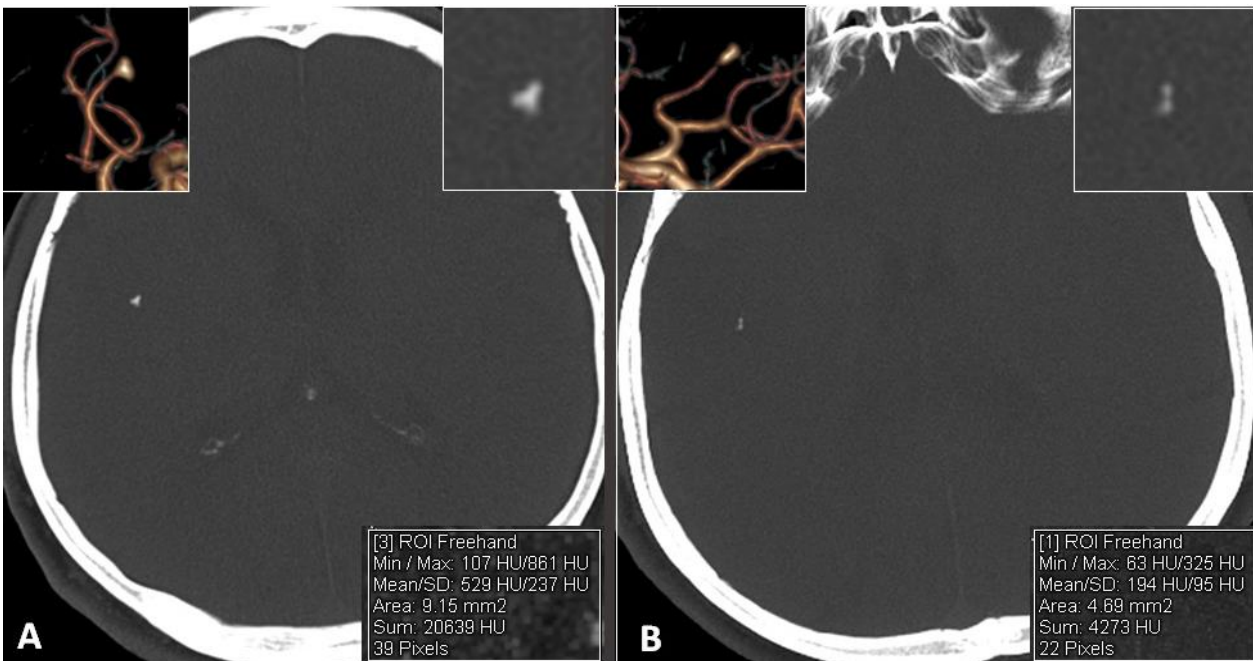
A: On unenhanced CT images with 12 mm thick MIP reformat at 30 F (bone filter), it is seen that the calcific emboli are in the shape of a starfish, and its total area is 9.15 mm². B: After IV tPA, the configuration of the calcified embolism changes and its area decreases to 4.69 mm². Images in the upper right corner represent magnified MIP images, and images in the upper left corner represent three-dimensional volume rendering images of calcified emboli.
